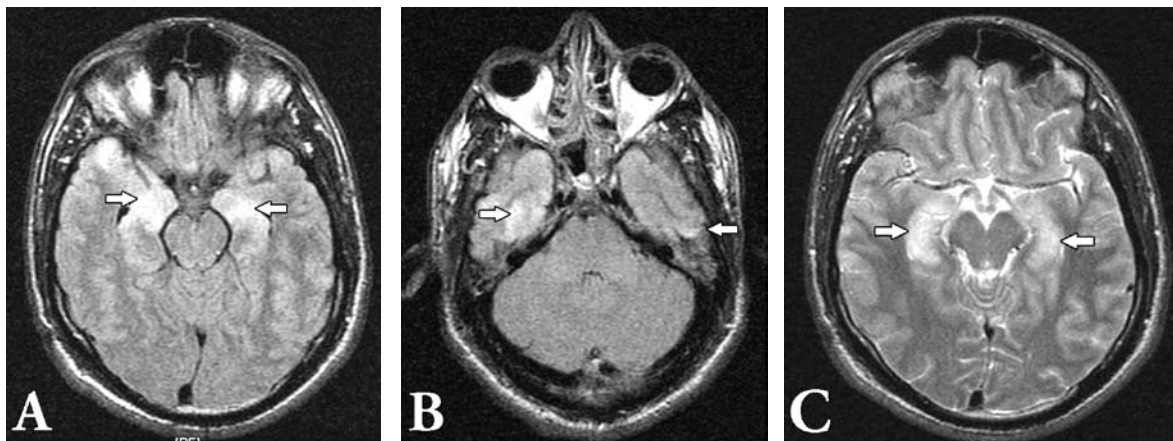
Magnetic resonance imaging of the brain of a young female with herpes encephalitis. It showed bilateral asymmetrical temporal lobe high signal intensities on FLAIR images (A and B) and T2 image (C).
